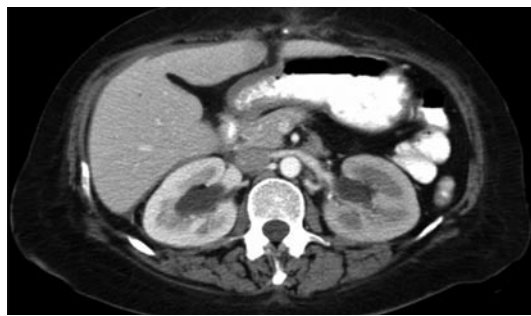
CT of abdomen showing bilateral hydronephrosis.
